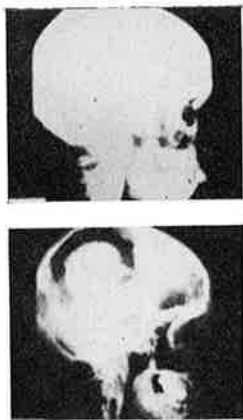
Contrast enhancement by television techniques. The top photo is the original X-ray while the lower is the same X-ray after contrast enhancement.
